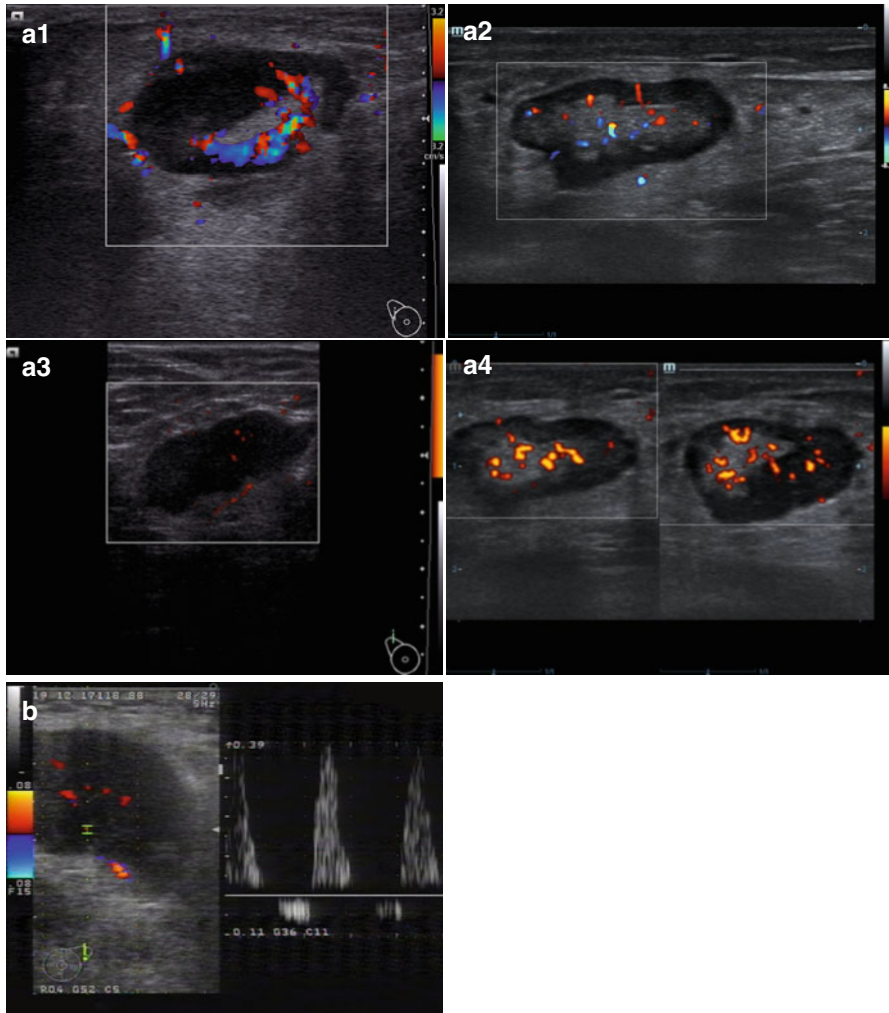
Metastases of breast carcinoma in axillary lymph nodes. (a) (1–4) CDI and PDI. (b) Pulsed Doppler. Abnormal blood flow spectrum with retrograde flow in late diastole
